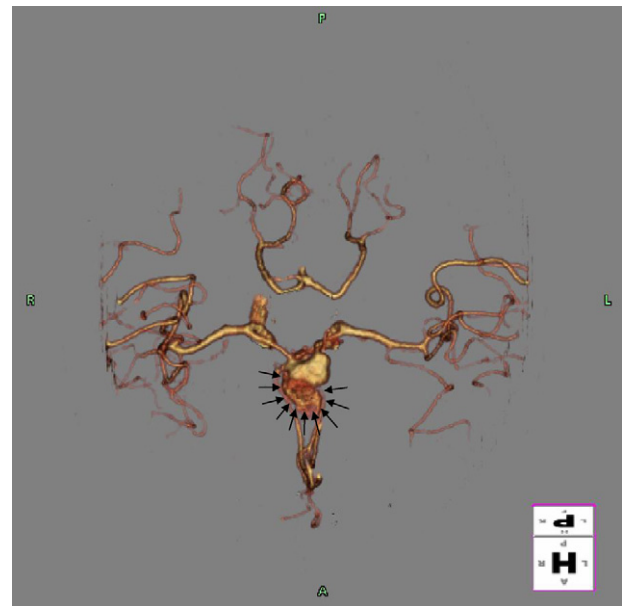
3D reconstruction of the CTA data. The arrowheads depict the anterior communicating aneurysm and the active hemorrhage.
